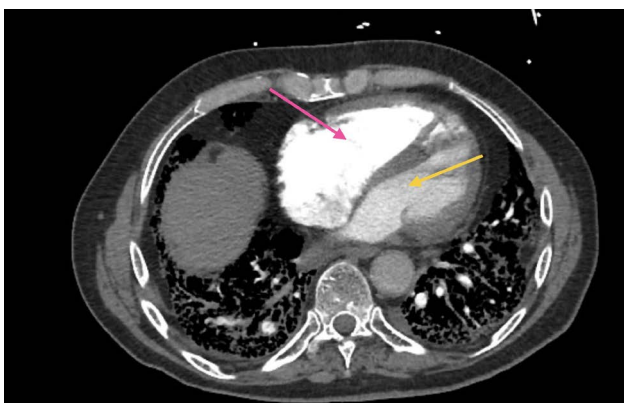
CT Chest with IV contrast, axial view, soft tissue window, at the level of ventricles demonstrating enlarged right ventricle (pink arrow) compared to left ventricle (yellow arrow), which is highly suggestive of pulmonary arterial hypertension or right ventricular overload
